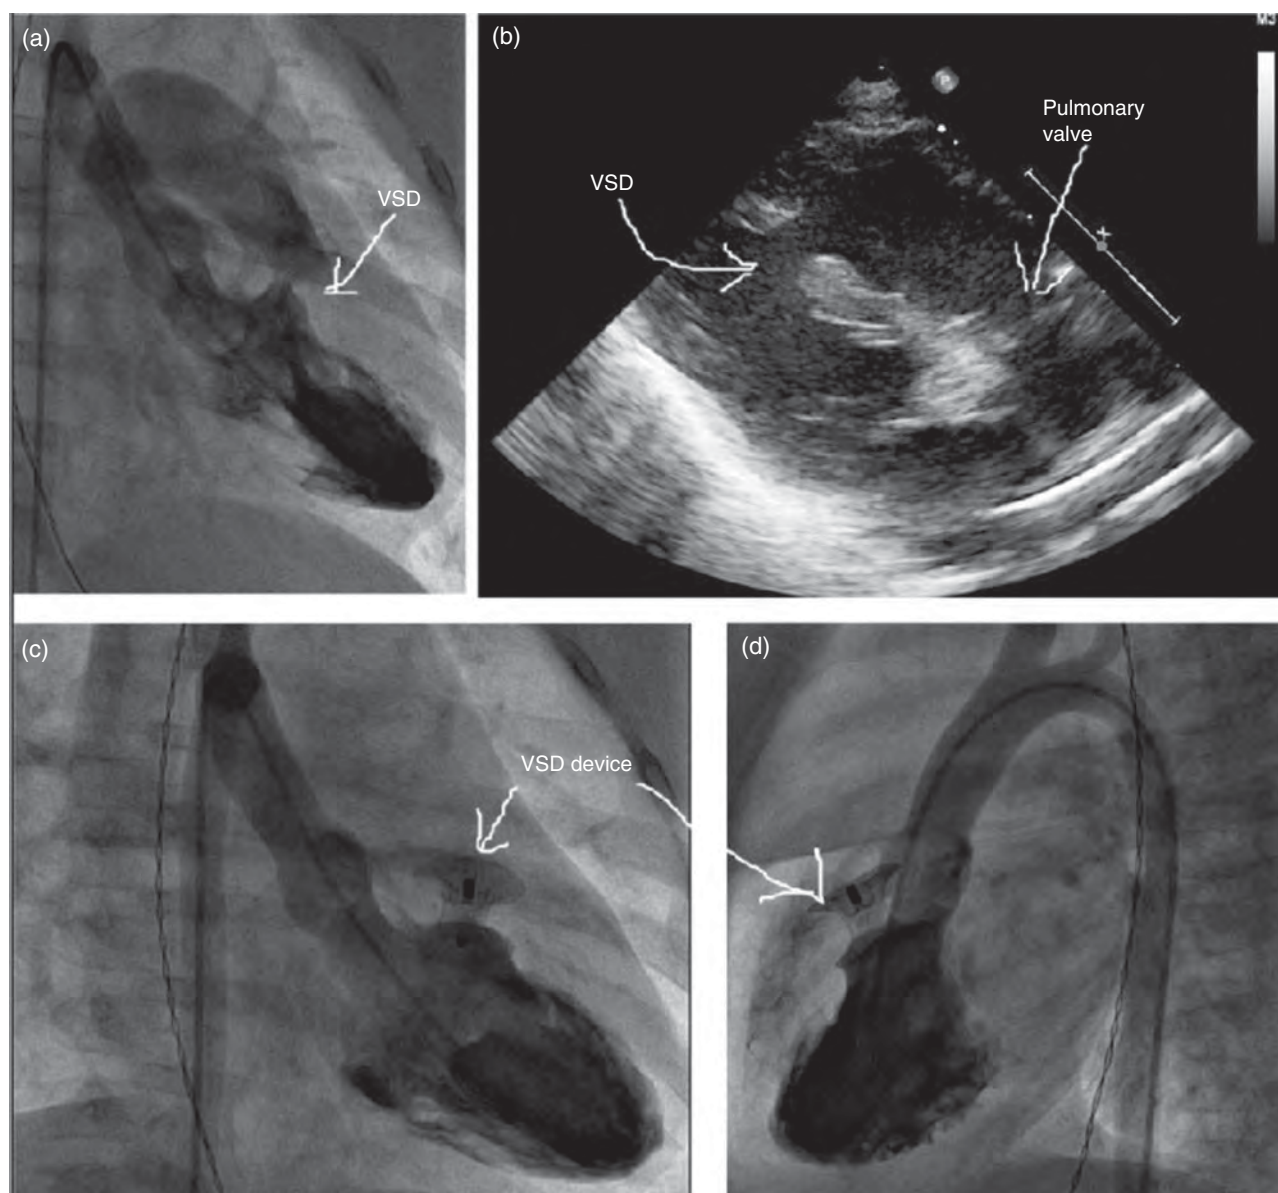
Anterior muscular defect: (a) long axial oblique angiography prior to intervention; (b) parasternal long-axis image showing the spatial relationship of the defect to the pulmonary valve; (c) long axial oblique; and (d) lateral view after device closure showing no residual shunt.
